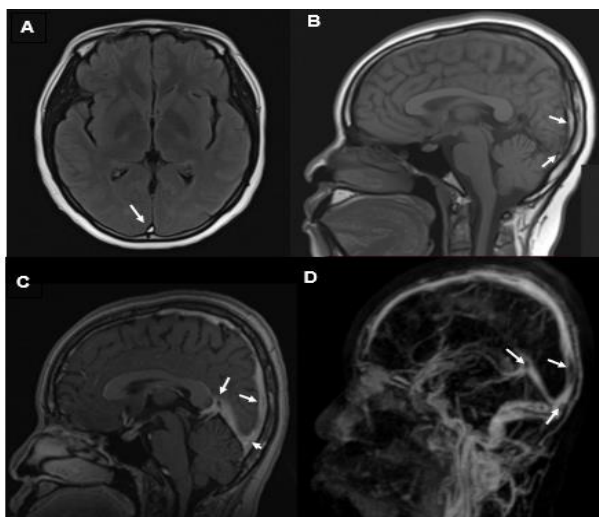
Brain magnetic resonance angiography (MRA) carried out three weeks after symptom onset. (A, B, C, D) The thrombus is observable as a hyper intense signal in the T2 FLAIR spin-echo (SE) sequence and in T1 SE without gadolinium at the location of the superior sagittal sinus. Conversely, it exhibits a hypo intense signal in T1 SE with gadolinium and during the magnetic resonance venography (MRV) at the superior sagittal sinus, the right sinus, and the Torcular Herophili.
